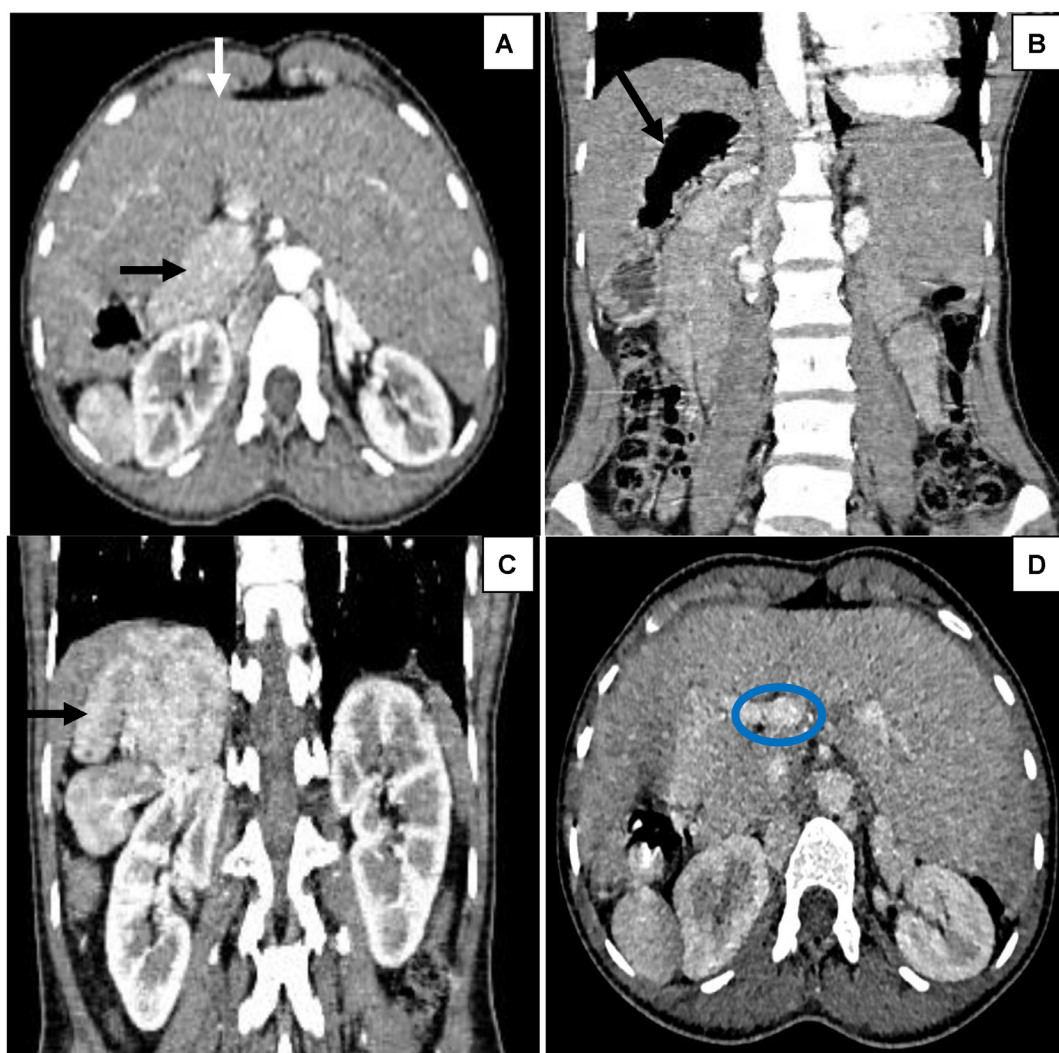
Abdominal CTA revealed an enlarged liver in a midline position (white arrow “A”). The pancreas was short, with agenesis of the corpo-caudal segments (black arrow “A”). The stomach was located in the right hepato-renal space (B), along with the presence of 3 ipsilateral splenules (C). Additionally, a predoduodenal portal vein was identified (D).
